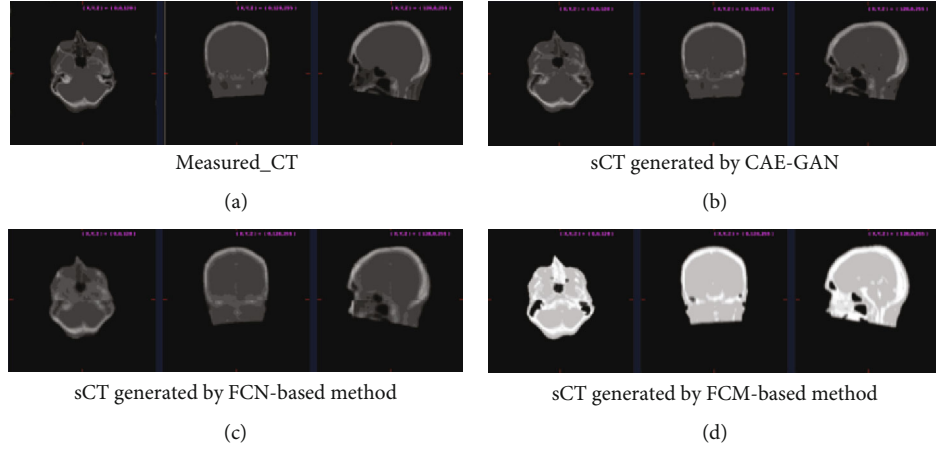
Results of different image synthesis algorithms on subject 1. (a) is the measured CT, and (b)–(d) are the synthetic CT generated by different methods. Each slice image is viewed from three perspectives, transverse, coronal, and sagittal, from left to right. It can be seen that (b) is the closest to the measured CT with high synthesis accuracy and quality.
